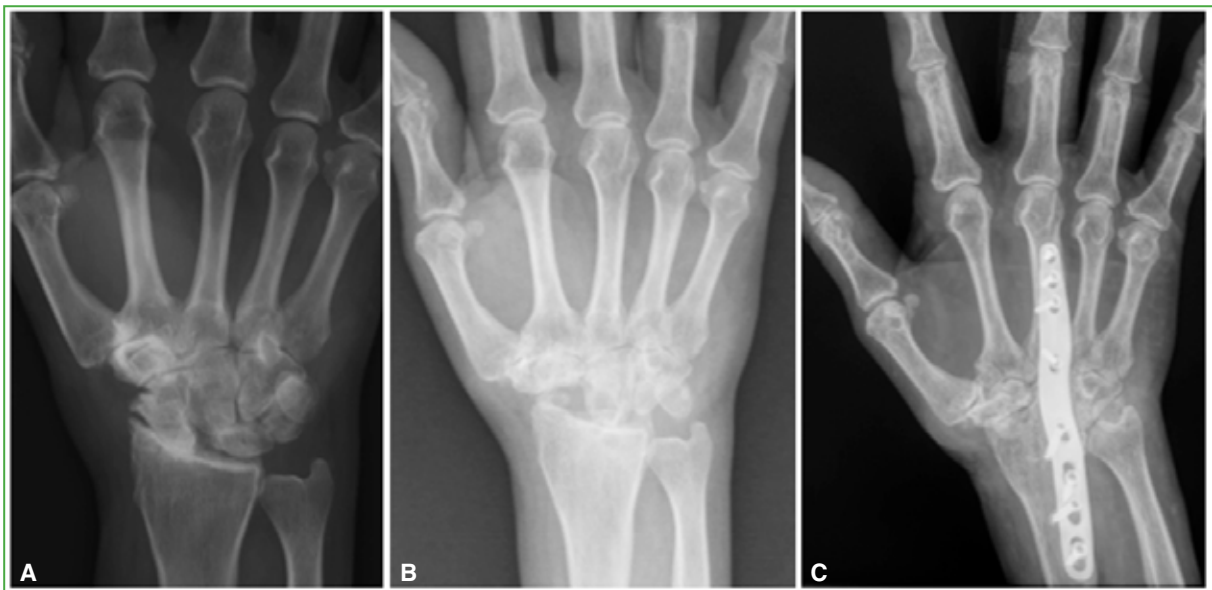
A. 57-year-old patient diagnosed with a SLAC wrist in the dominant hand. B. Poor clinical and radiographic evolution after proximal row carpectomy, with progression of osteoarthritis between the capitate bone and the radius. C. New intervention with total wrist arthrodesis, with good outcomes.
